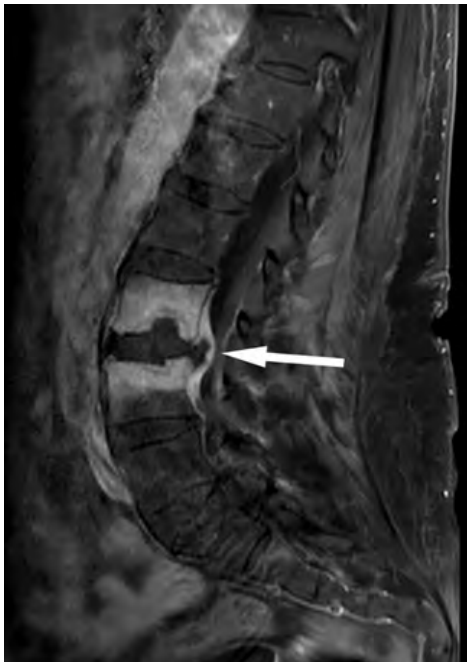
MRI lumbar spine post contrast sagittal image demonstrates avid enhancement involving the L3 and L4 vertebral bodies with associated endplate deformities
